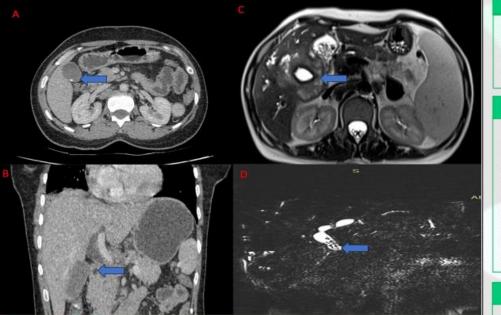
CT image showing distended gallbladder with thick walls containing calculus (blue arrow) and a dilated common bile duct with distal abrupt tapering. Figure 1C, 1D: MRCP showing irregular GB wall thickening with infiltration of the adjacent liver parenchyma with bilobar intra-hepatic biliary dilatation, and dilated CBD with multiple intraluminal filling defects (blue arrow).
